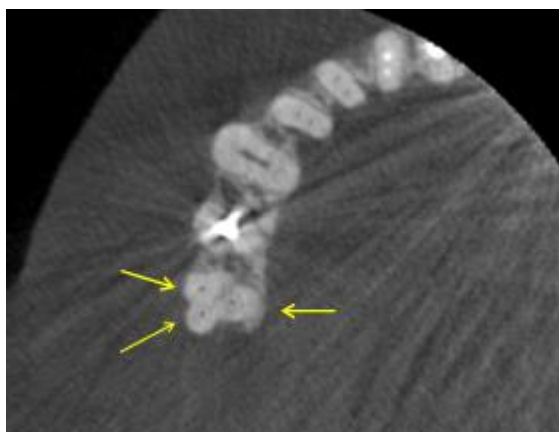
The CBCT image of mandibular right area; it is visualizing three canals in root of the second premolar (yellow arrow).
